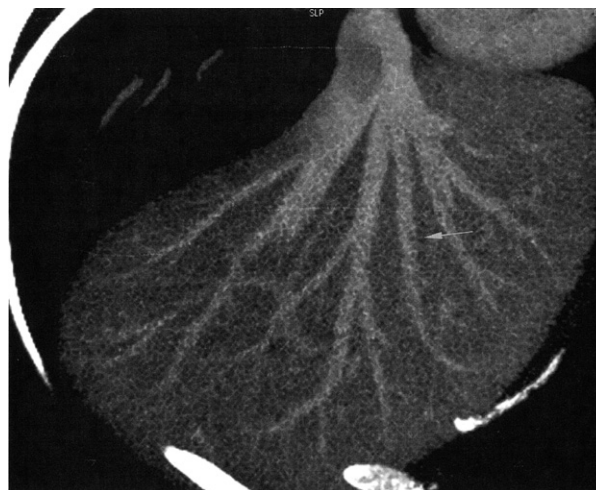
CT angiographic image of segment 4b vein.
